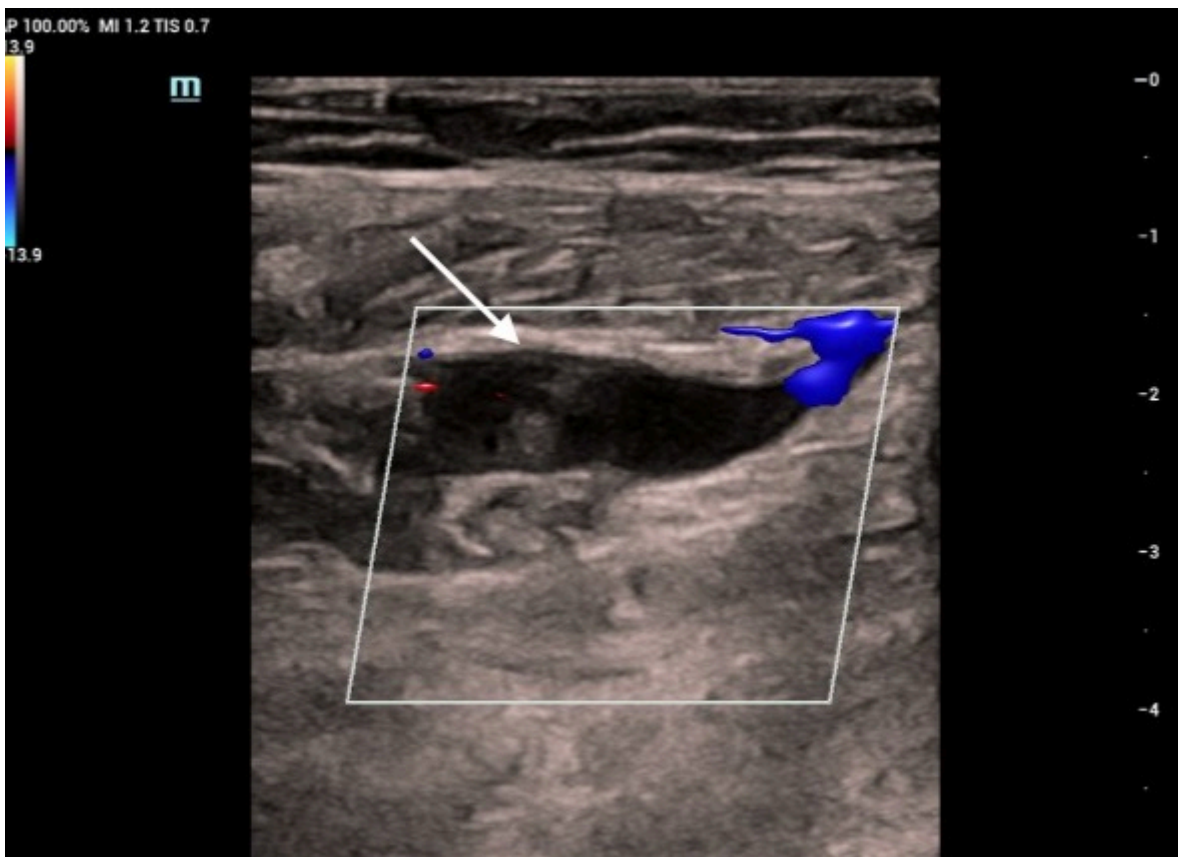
Transverse color doppler image of the same structure. There is flow in the more superficial position of this structure within the muscle. The area with no flow is dilated markedly compared with the area of flow that connects with normal superficial veins and deep veins.
